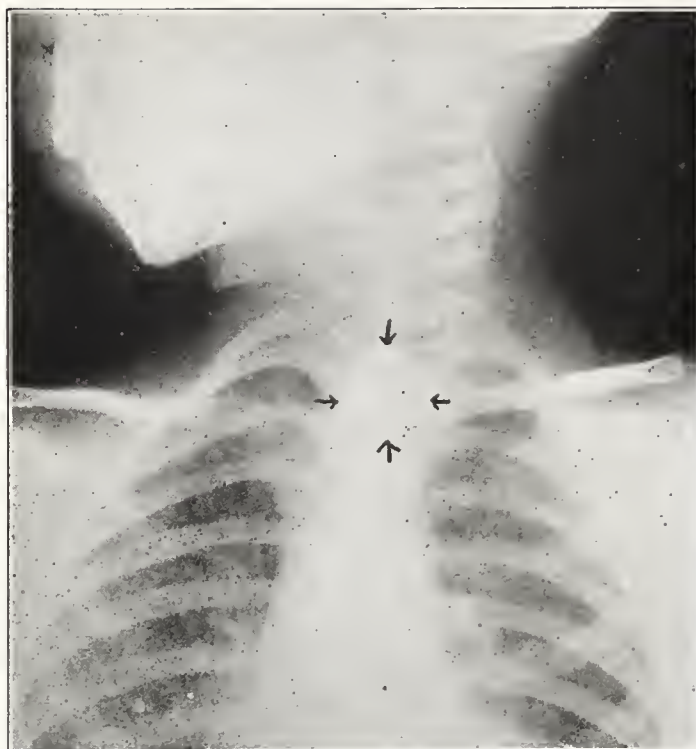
Coin in the esophagus: The coin was removed by esophagoscopy and the patient made an uneventful recovery. It is important to differentiate tracheal from esophageal foreign bodies. Foreign bodies in the esophagus have their widest surface showing on the anteroposterior x-ray plates, but tracheal foreign bodies show up best on the lateral plate. This difference is accounted for by the necessity of the foreign body assuming an anteroposterior position in order to pass between the vocal cords into the trachea. The opposite plane must be assumed to pass behind the larynx into the esophagus. (Compare with Fig. 4.)
